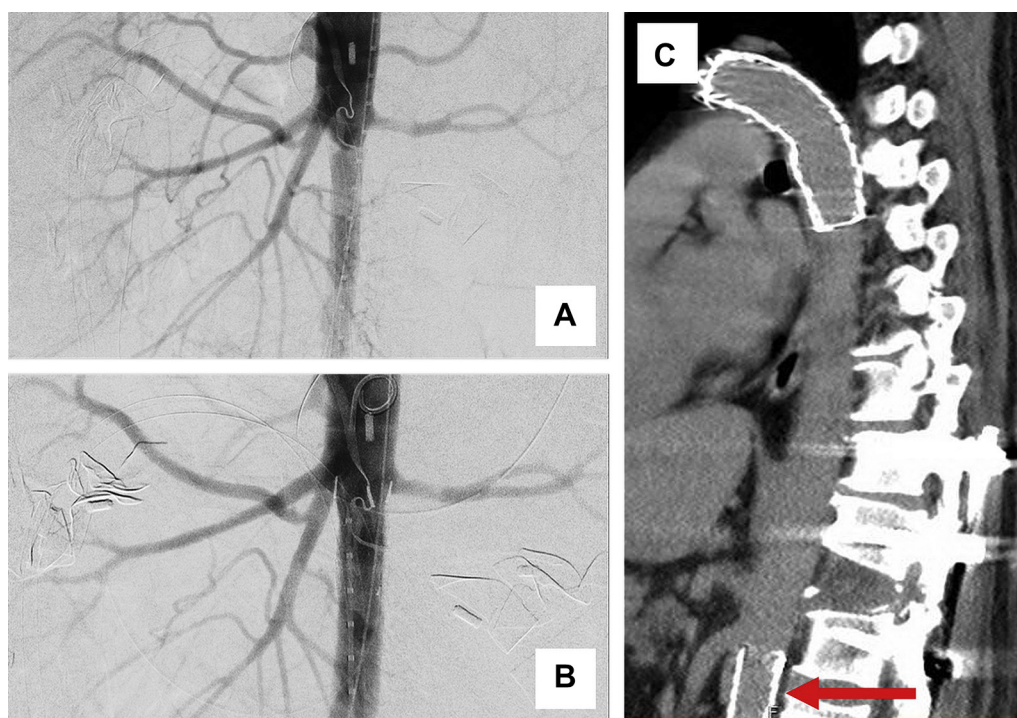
A, The intraoperative angiogram obtained before graft deployment demonstrates the abrupt infrarenal diminution in aortic diameter seen in Fig 1, A-C. B, Completion angiogram demonstrating improvement in aortic diameter after graft deployment. C, Sagittal view from computed tomography angiography (CTA) of the chest done 1 month after injury and repair. The inferiormost extent of this study demonstrates the superiormost aspect of the abdominal endograft with continued exclusion of dissection.
